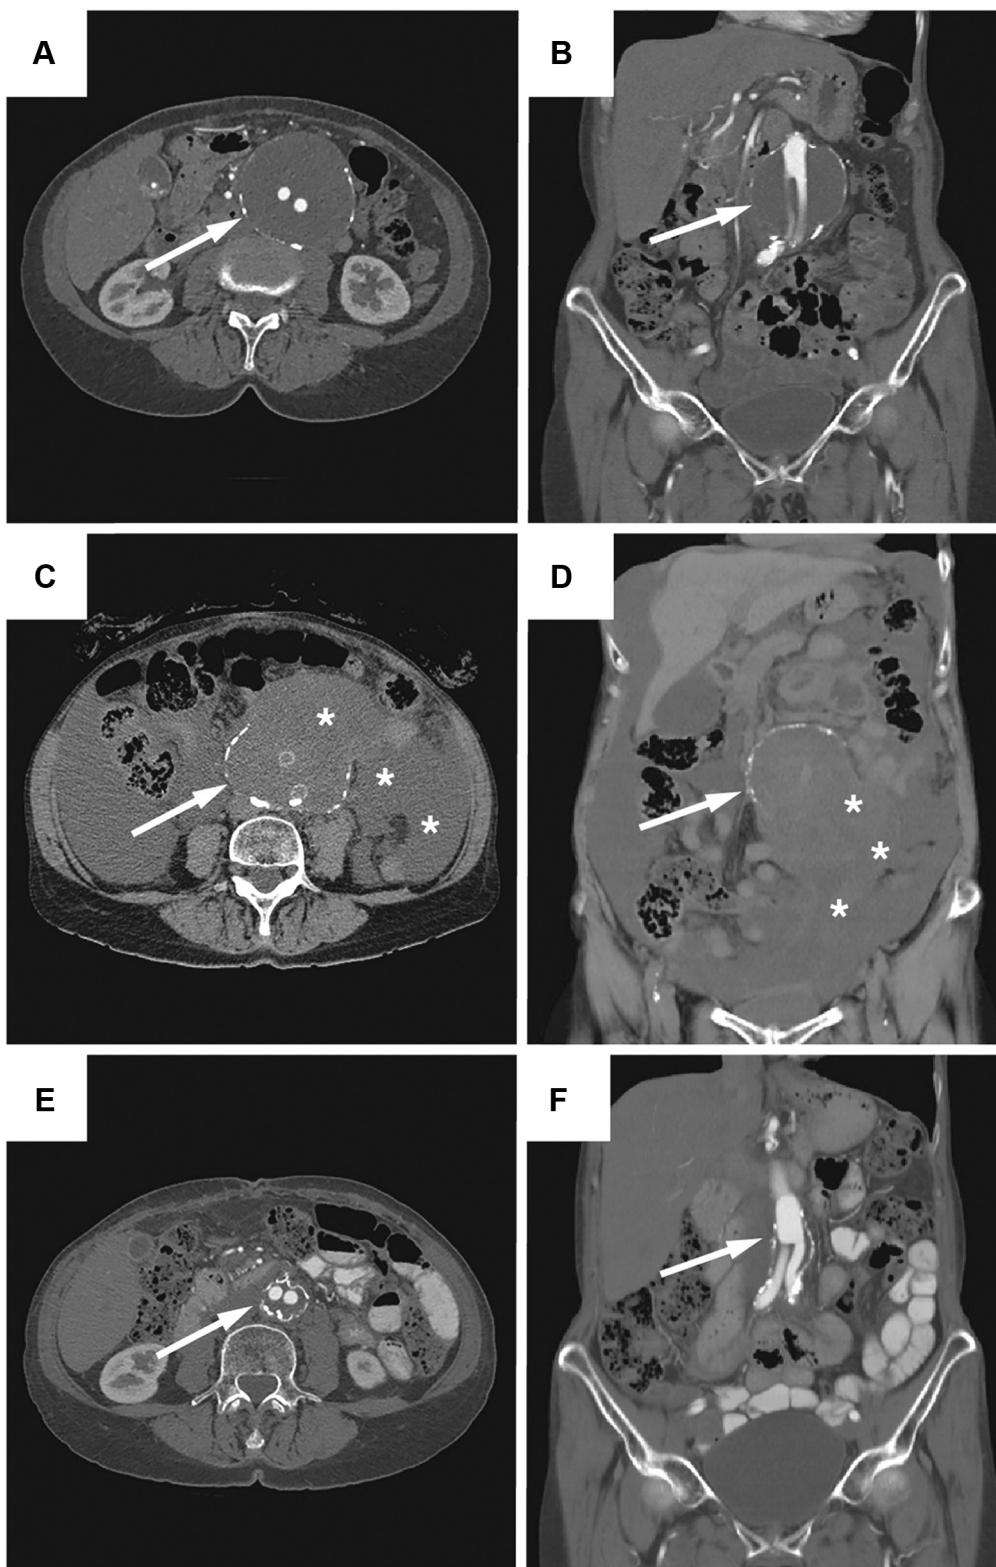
Representative images from computed tomography (CT) angiogram shows (A and B) the encapsulated perigraft seroma (arrow) with a diameter of 10 cm, and (C and D) the ruptured perigraft seroma (arrow) with free fluid in the intra-peritoneal cavity (*). E and F, Three months postoperative images showing no sign of perigraft seroma (arrow). (Printed with permission from the patient.)
